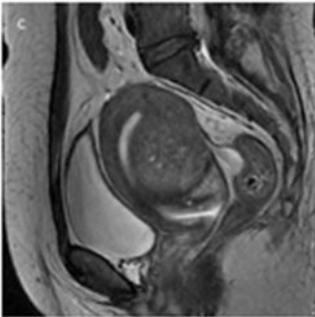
c: The sagittal of T2-weighted imaging
